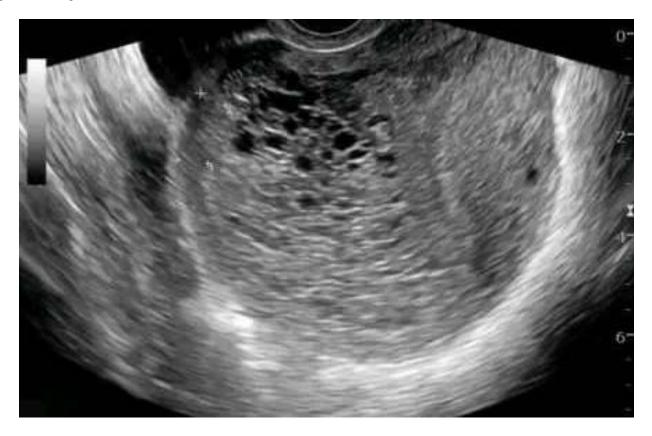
Ultrasound image showing a "grape-like" appearance filling the uterine cavity, suggestive of a complete hydatidiform mole.
